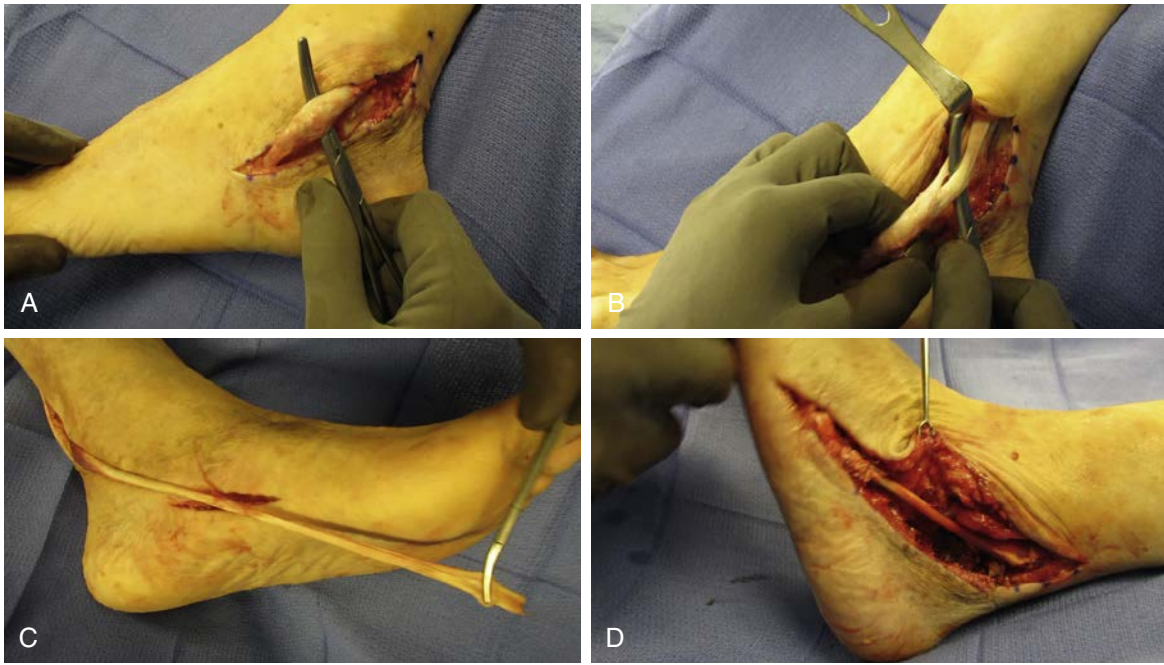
This patient had undergone two prior surgeries with a tenodesis of the longus to the brevis as the last procedure. (A) Note the markedly thickened tendon. (B) The tendon was noted to be torn at the level of the prior attempted tenodesis. There was no good muscle noted on magnetic resonance imaging (MRI) of the leg, and a transfer of the flexor hallucis longus FHL was performed. (C) Note the length of the tendon that can be obtained by cutting the tendon under the interphalangeal (IP) joint of the hallux. (D) The FHL tendon is passed through a drill hole in the base of the fifth metatarsal and then sutured back on itself for excellent fixation, which will facilitate immediate bearing of weight.
